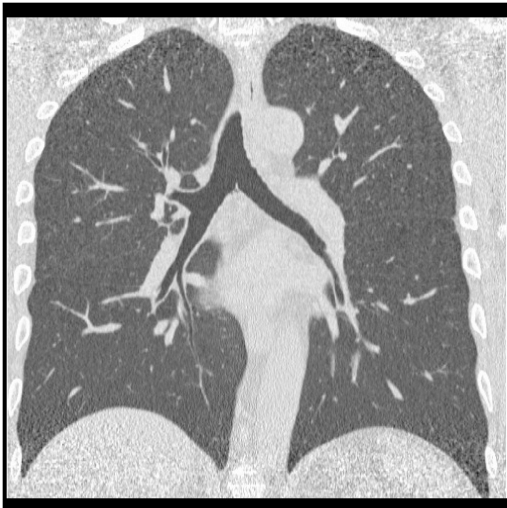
Coronal view reconstructed from 2-mm-interval, 2-mm slice thickness CT images acquired during low-dose multislice CT lung cancer screening in which scanning protocols were 15 mAs, and 1mm X 16 rows.
